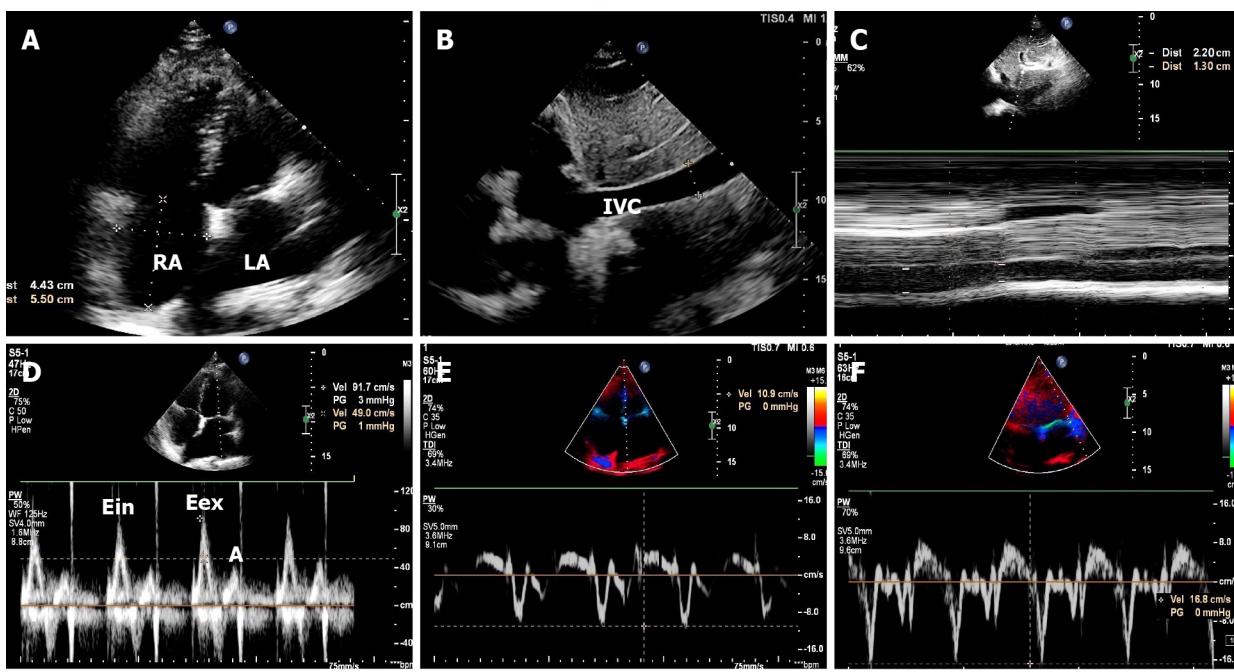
Echocardiographic examinations after pericardiocentesis. A: Right atrial (50 mm × 62 mm) and left atrial (61 mm × 61 mm) enlargement, increased pericardial thickness, and pericardial effusion that was located predominantly along the apical wall (measuring up to 1.2 cm); B and C: Dilated inferior vena cava (up to 2.5 cm) almost without any respiratory variation (20%), indicating an elevated right atrial pressure of approximately 20 mmHg; D: Pulsed wave doppler of the mitral valve showed that the peak mitral E and A inflow velocity were 90 cm/s and 38 cm/s, respectively. The E/A ratio was > 2, indicating restricted mitral inflow velocity. Respiratory variation in the peak mitral E inflow velocity was 28% (peak E velocity during expiration and inspiration were 90 cm/s and 65 cm/s, respectively); E and F: Tissue Doppler imaging showed “annulus reversus” with the lateral mitral e' velocity (12.9 cm/s) abnormally lower than the medial mitral e' velocity (14.9 cm/s). IVC: Inferior vena cava; LA: Left atrium; RA: Right atrium.
